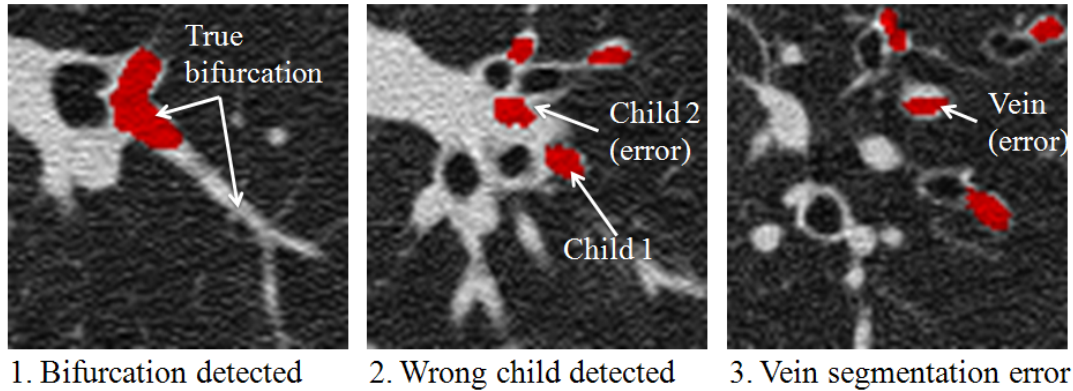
Three frames from a single CT image showing the progression of a leak onto the inferior pulmonary vein.
